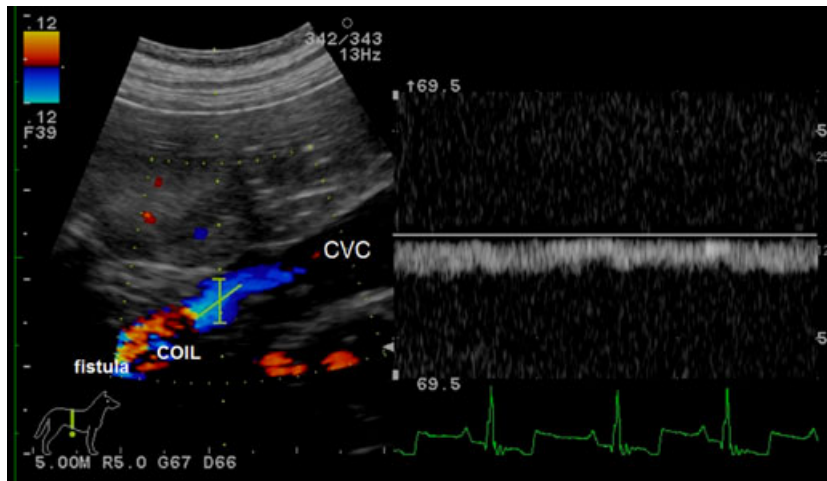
Postoperative Doppler image of the caudal vena cava. Spectral Doppler taken after 2 months indicated no arterial inflow in the CVC.
